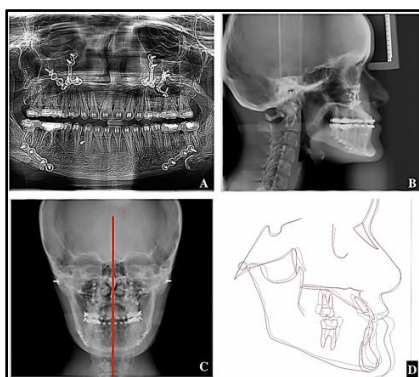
(A) Post-surgical orthopantomogram; (B) Post-surgical lateral cephalogram; (C) Post-surgical pa cephalogram showing coinciding midlines; (D) Pre-Surgical
